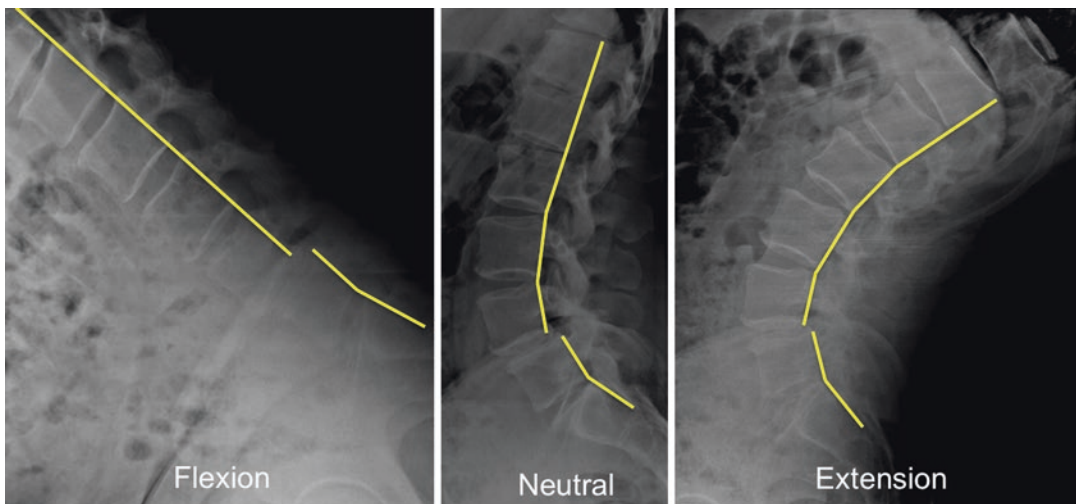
Dynamic radiography of the lumbar spine: upright flexion–neutral–extension lateral projections. Grade I anterolisthesis at L4–L5 level is appreciable (yellow lines)
